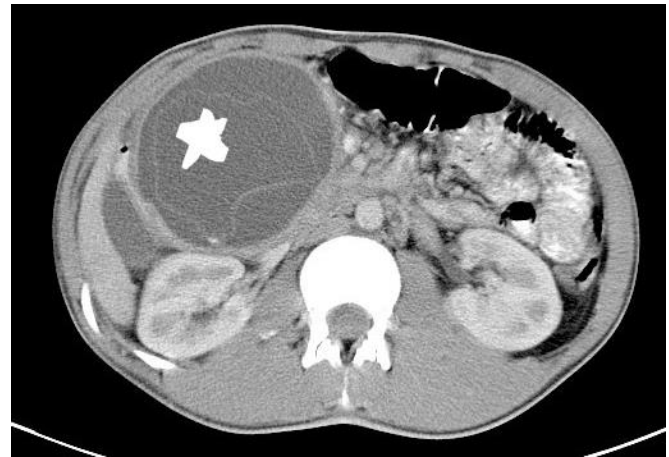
CT of abdomen showing thin walled decreased attenuating lesion (indicated by star) having multiple thin walled septations, measuring approximately 94 x 98 mm in longest dimensions.
